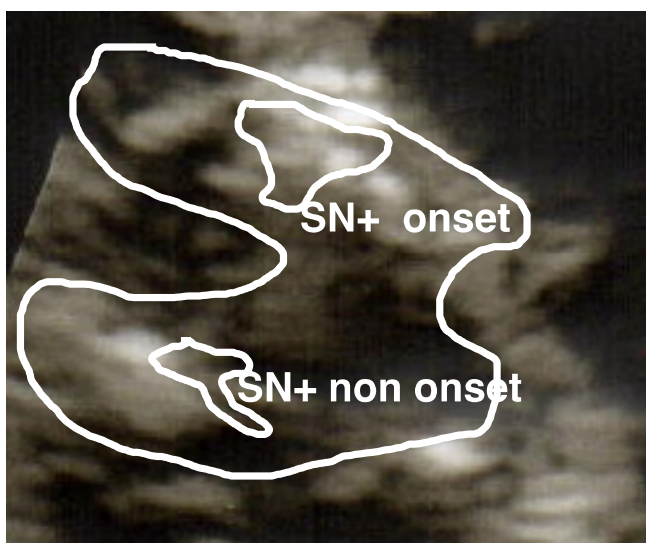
Sonographic image of substantia nigra hyperechogenicity (SN+) in PD patient.
